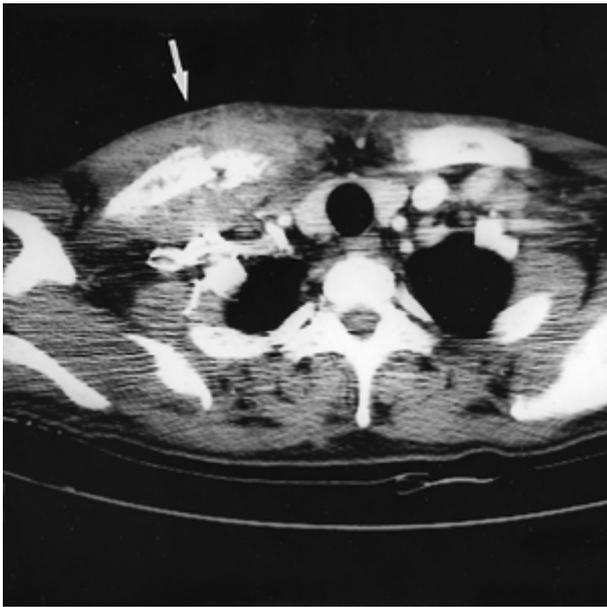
Chest CT scan shows relatively well-margined 5×8 cm sized soft tissue mass (arrow) in right clavicular area with pathologic fracture of clavicle.
